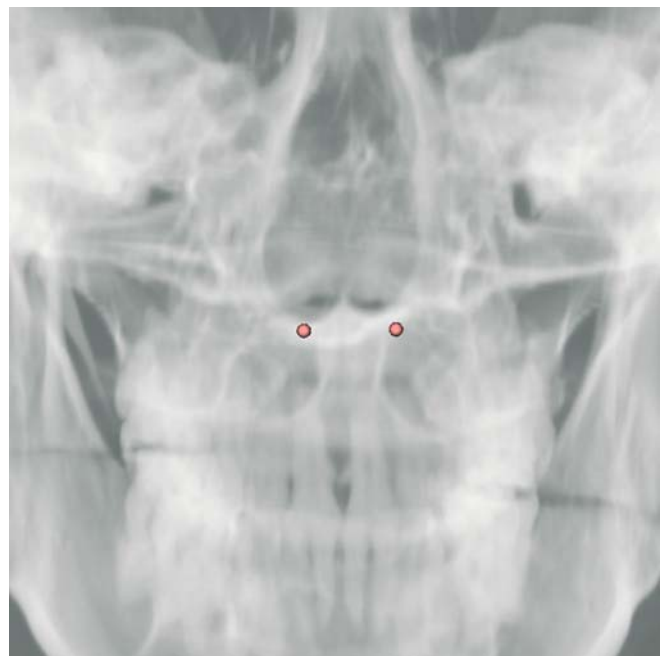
Posterior Maxillary Point ($PMP_r - PMP_l$) landmarks. Virtual frontal cephalogram (3-D CT, patient K.C.)
